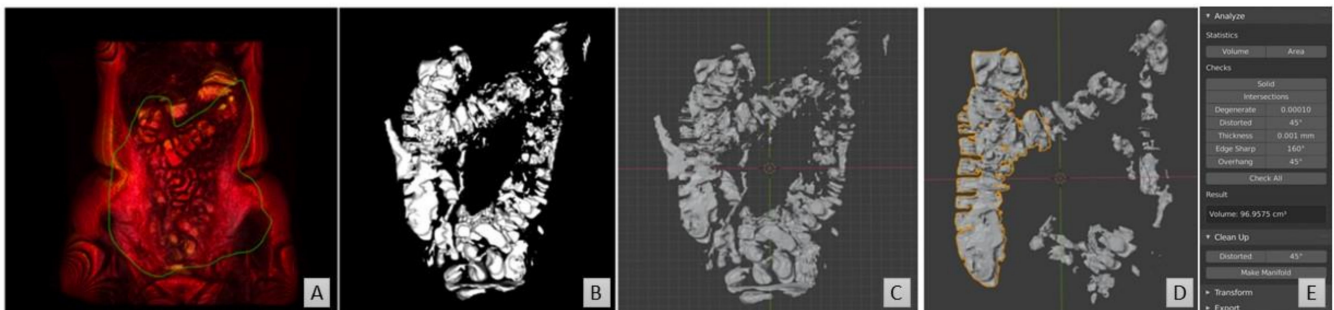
Representative images from the 3D protocol, MRI dataset taken from a 15-year-old female. (A) The 3D rendering in Horos builds a 3D model of the entire dataset. (B) The colon was excised from the 3D model in Horos. (C) The model converted into an STL file and opened in Blender. (D) Non-colon artefacts are removed. (E) The volume of the individual pockets is calculated in Blender.
